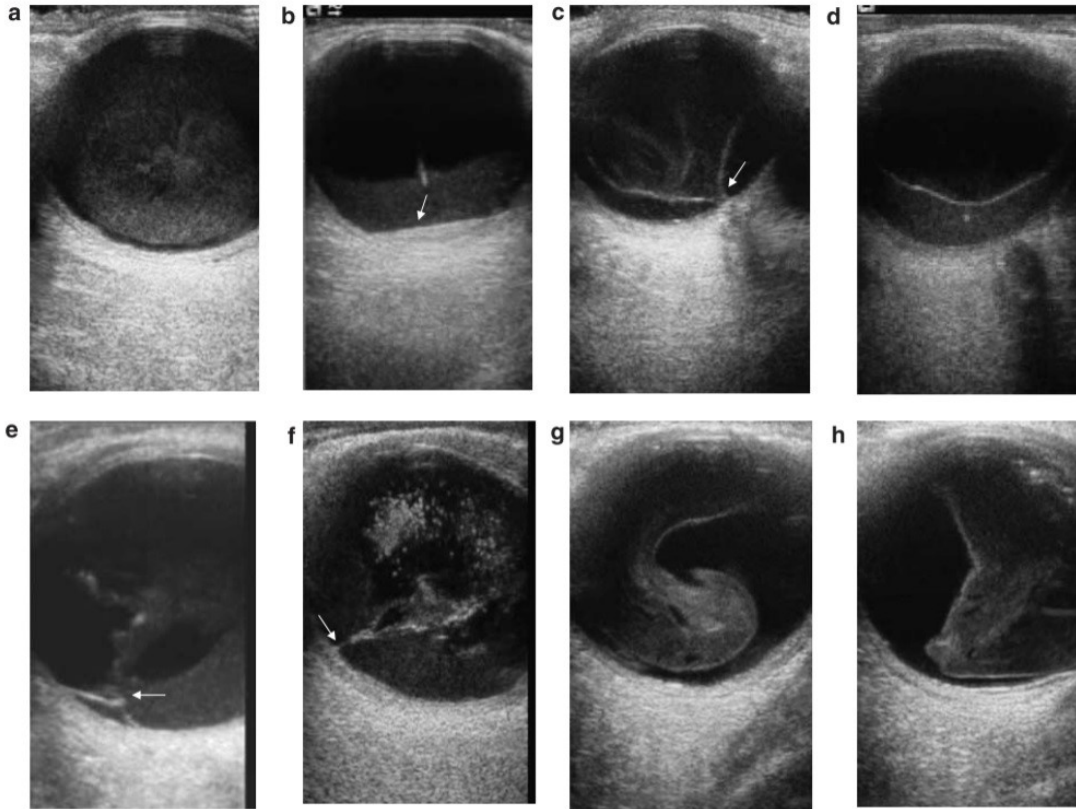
B-Scan ultrasound of vitreous hemorrhage. a: Intragel hemorrhage with PVD. b: retrohyaloid hemorrhage with PVD. c: intragel and retrohyaloid hemorrhage with incomplete PVD. d: intragel and retrohyaloid hemorrhage with PVD. e: deviated gaze; temporal retinal tear with retrohyaloid and central gel hemorrhage (clear cortical gel). f: deviated gaze; asteroid hyalosis with retrohyaloid hemorrhage and vitreoretinal adhesion at site of a BRVO. g: laterally deviated gaze: movement of intragel hemorrhage. h: same eye as in g; nasally deviated gaze; movement of intragel hemorrhage.⁵² Abbreviations: PVD= posterior vitreous detachment; BRVO= branch retinal vein occlusion. Used with the kind permission of Springer Nature.
